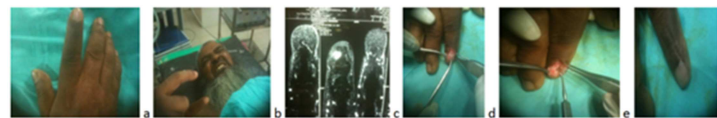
a. pre operative image of 50 yrsmale, glomustumor radial border at subungualregion of right index finger. b. Pin point tenderness atlesional area. C. MRI of right index finger. d. per operative appearence. e. after removal tumor. f. post operative appearance at one month
